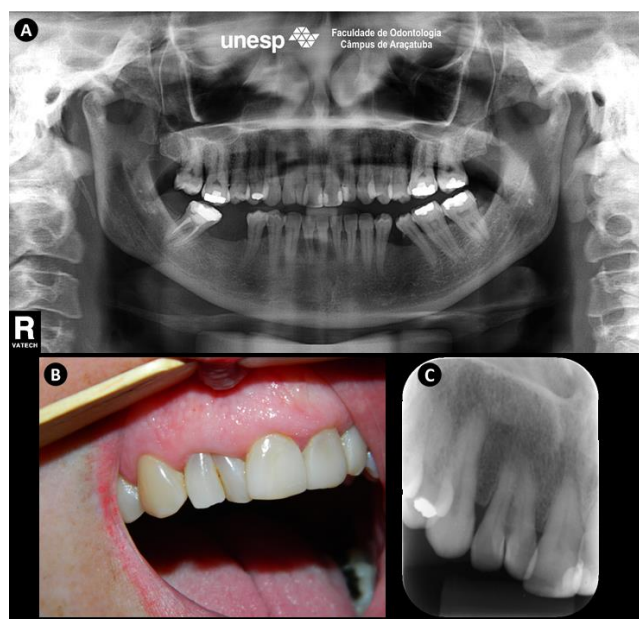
A) Panoramic radiography with alteration at the maxillary right (tooth12). B) Buccal view of the bifid crown; note the absence of interdental papilla. C) Periapical radiograph of the right upper lateral incisor (tooth12) with fusion of a supernumerary tooth and the tooth 12, showing two roots and two crowns.
